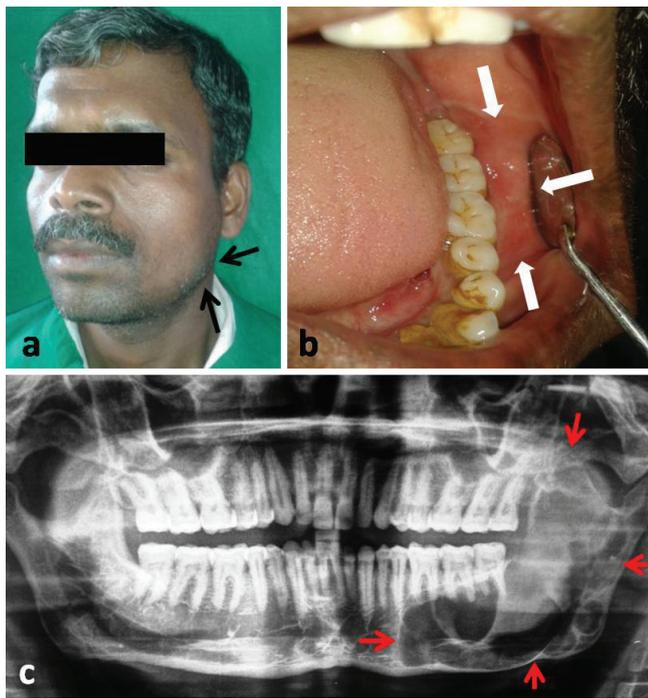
Clinical presentation of lesion; (a) diffuse swelling over left mandibular angle and ramus region, (b) intraoral view showing expansion of buccal cortical plate and obliteration of buccal vestibule, (c) Orthopantomogram showing well defined, corticated multilocular radiolucency in left mandibular body, angle and ramus region.
